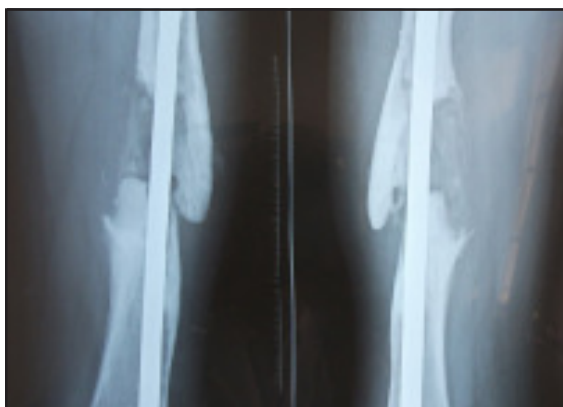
X-ray Photograph showing one month after surgery on first follow up visit.
